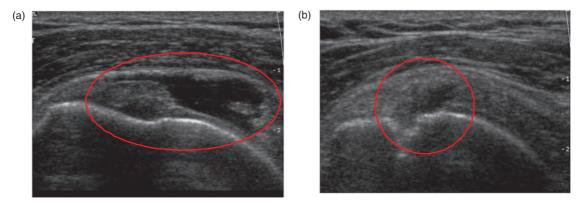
Ultrasound images of supraspinatus tendon. (a) Full thickness tear; (b) partial thickness tear.
